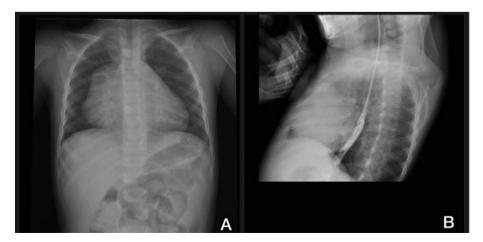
X-ray chest AP view post upper GI endoscopy showed an irregular right cardiac shadow with a bulging right side of the heart (A). X-ray chest lateral view.
